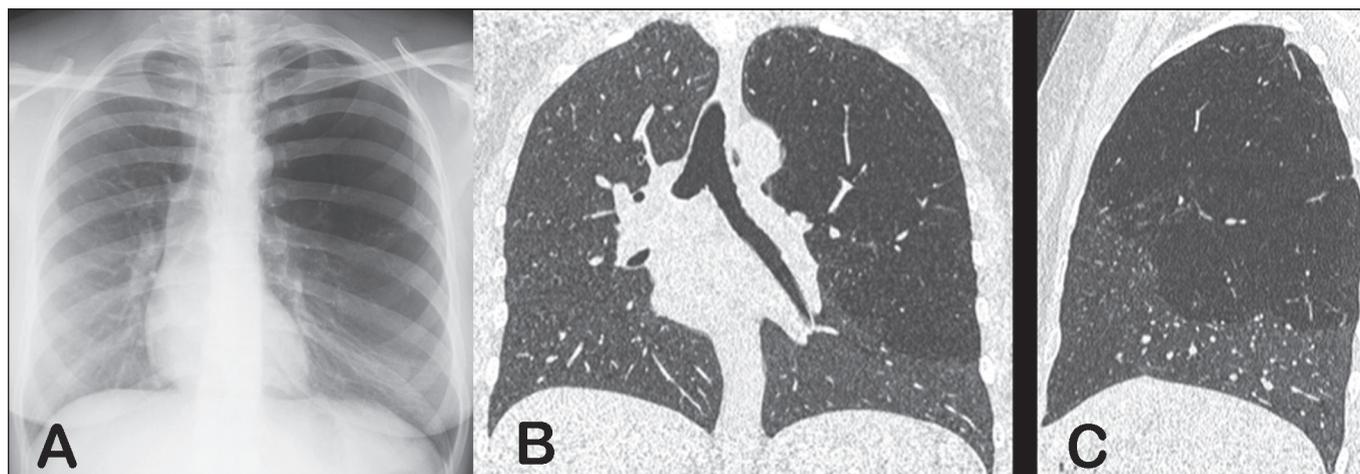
Anteroposterior chest X-ray (A) showing radiolucency and hyperinflation of the upper two thirds of the left lung. HRCT with coronal and sagittal reconstructions (B and C, respectively) showing hyperinflation of the left upper lobe of the lung, as well as vessel attenuation.
